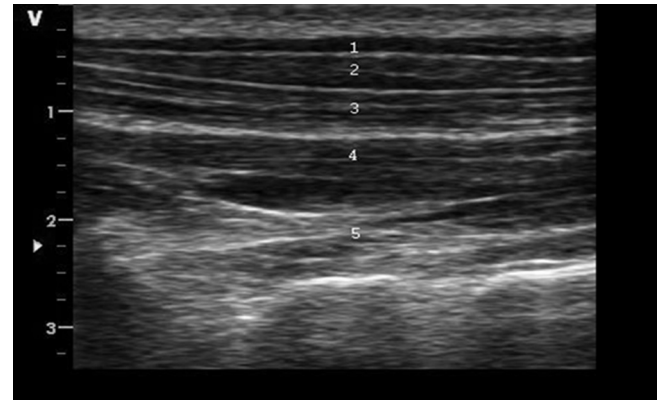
Ultrasound image, dorsal view superficial and deep cervical muscles. 1 = Trapezius, 2 = Splenius, 3 = Semispinalis Capitis, 4 = Semispinalis Cervicis, 5 = Multifidus. Vertical axis in the figure shows the depth of the imaging into the tissues.
